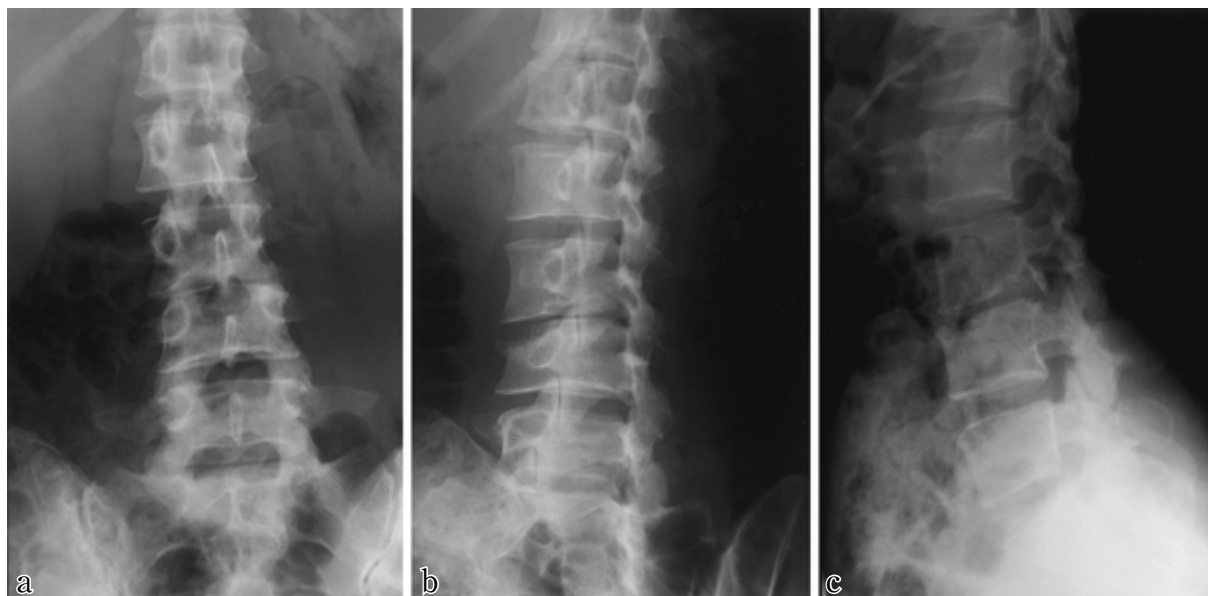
Radiographs at admission to our hospital (September 1998). X-ray examination reveals advanced disc space narrowing of L 3/4 and destructive changes in antero-superior portion of L 4 vertebral body. Fig. 3-a: AP view, Fig. 3-b: Oblique view, Fig. 3-c: Lateral view
